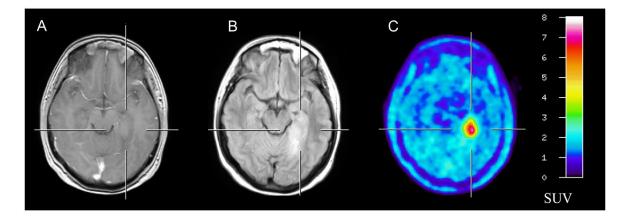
Patient with an unclear non-enhancing lesion in the left temporal lobe. The true extent of the tumor and the metabolically most active tumor parts for biopsy guidance are difficult to identify in the contrast-enhanced T1-weighted (A) and in T2-weighted MRI (B) but clearly depicted in [¹⁸F]-FET- PET (C). Neuropathological evaluation of tissue obtained by biopsy revealed the diagnosis of glioblastoma.
